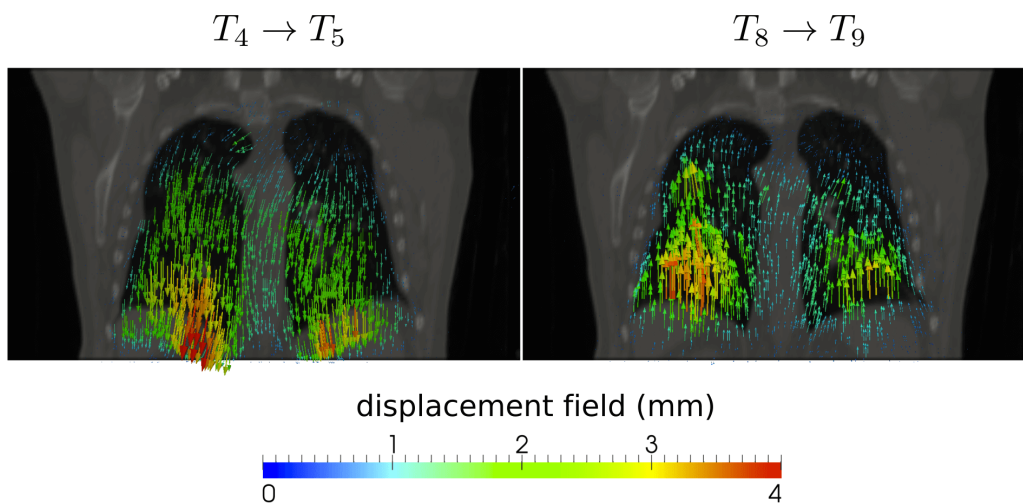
Two exemplary computed transformations visualised via displacement vectors in a coronal slice of the CT image. The transformation $T_4 \rightarrow T_5$ corresponds to the state at end inspiration and shows a downwards vectored motion direction with maximum values in the region of the diaphragm (left). The transformation $T_8 \rightarrow T_9$ corresponds to the last state before end expiration and shows an upwards vectored motion (right).
